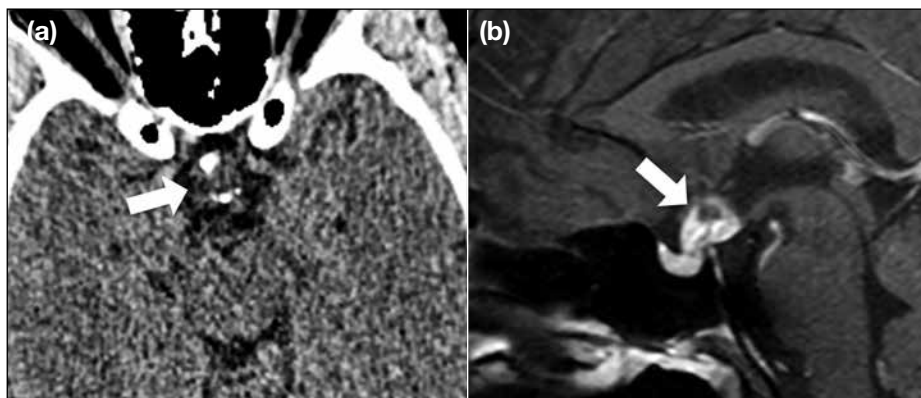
Adamantinomatous craniopharyngioma. Calcification is identified in the suprasellar tumour (arrow) on axial nonenhanced computed tomography (a) with strongly enhancing soft tissue and cystic portions of the tumour (arrow) on sagittal T1-weighted fat-suppressed image (b).
